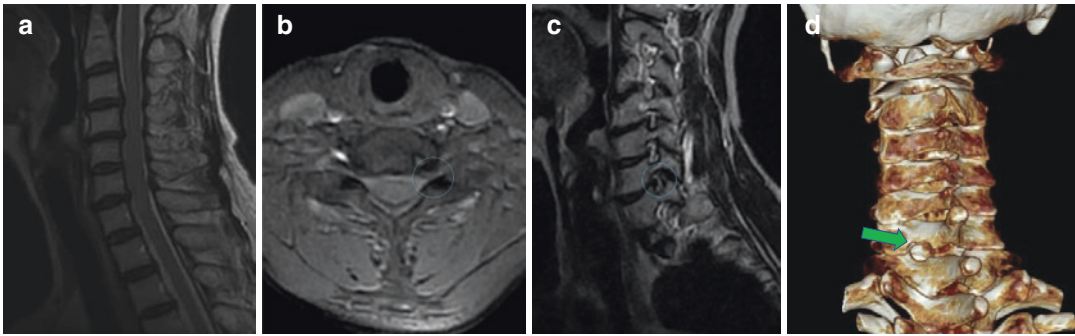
Pre-operative MRI (a, b, c) showing severe foraminal stenosis at C6–C7 level on the left side (circled). Post-operative posterior view of a 3D CT (d) scan
